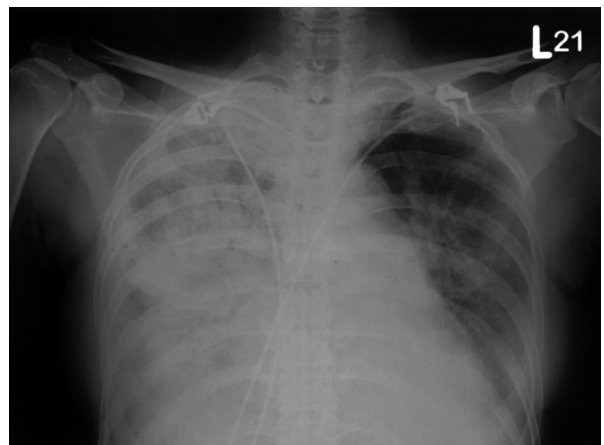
Chest X-ray showing heterogenous airspace infiltrates in the right lung with pleural effusion and opacification in the left lower chest.
